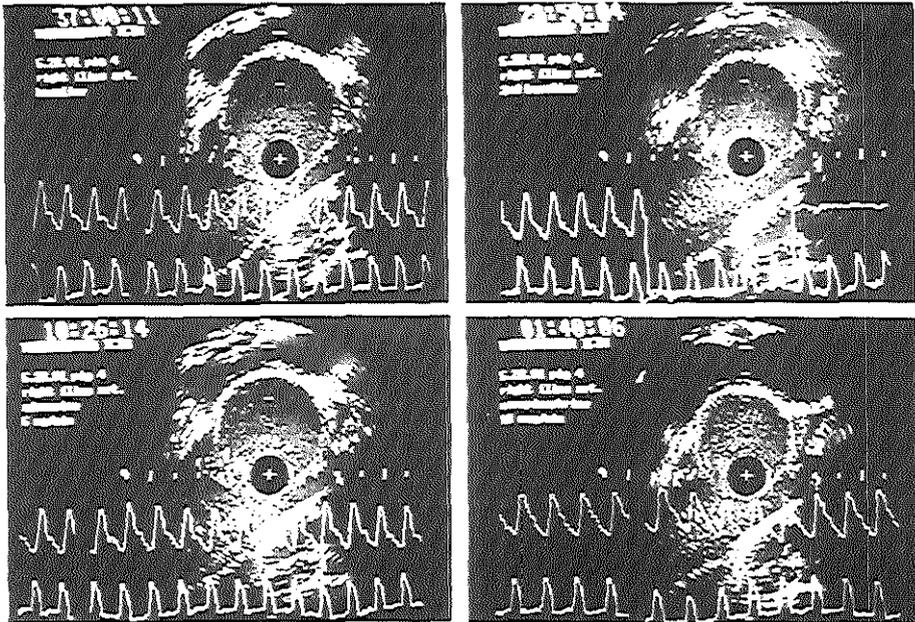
Intravascular ultrasound end-diastolic images of baseline (upper left panel), during adenosine (lower left panel), second baseline (upper right panel), and during norepinephrine (lower right panel) demonstrate the absence of vasodilation in response to adenosine but the presence of vasoconstriction in response to norepinephrine.
